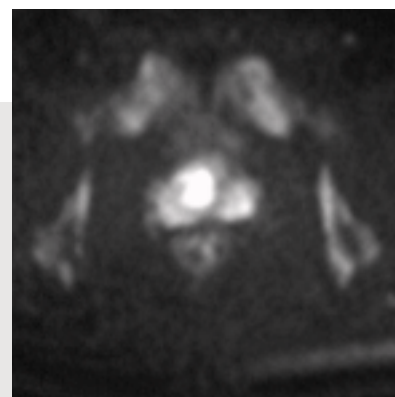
Diffusion-weighted image – DWI ($b = 1000$)
